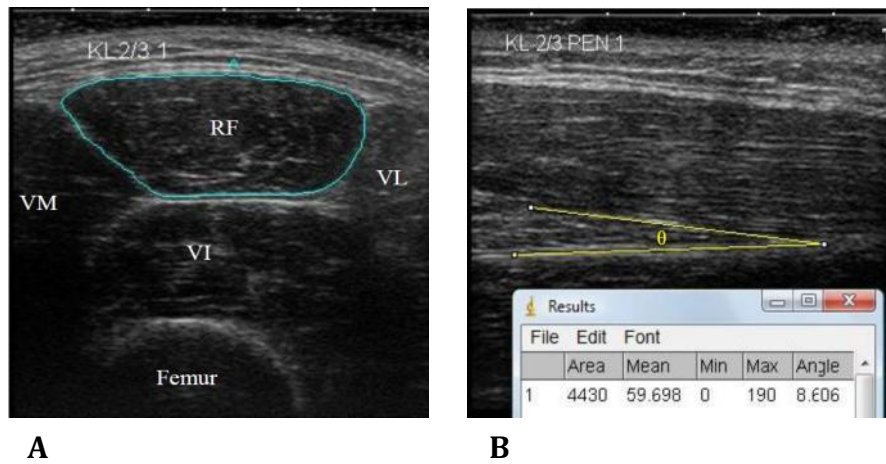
Ultrasonographic images of rectus femoris muscle structure
